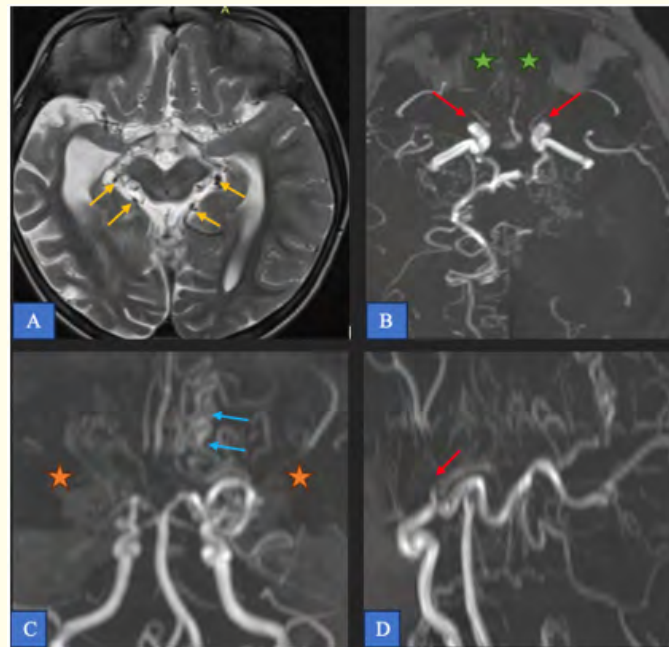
A: T2 axial weighted imaging of MRI showing multiple flow voids related to collateral vessels called moyamoya vessels (yellow arrows). B-D: Axial (B), coronal (C), and sagittal (D) TOF (time of flight) MRA showing severe stenosis of the supra-clinoid portion of both internal carotid arteries (red arrows), with absent flow in the anterior (green asterisks) and middle cerebral arteries (orange asterisks), and the development of a moyamoya collaterals in a "puff of smoke" pattern (blue arrows).
